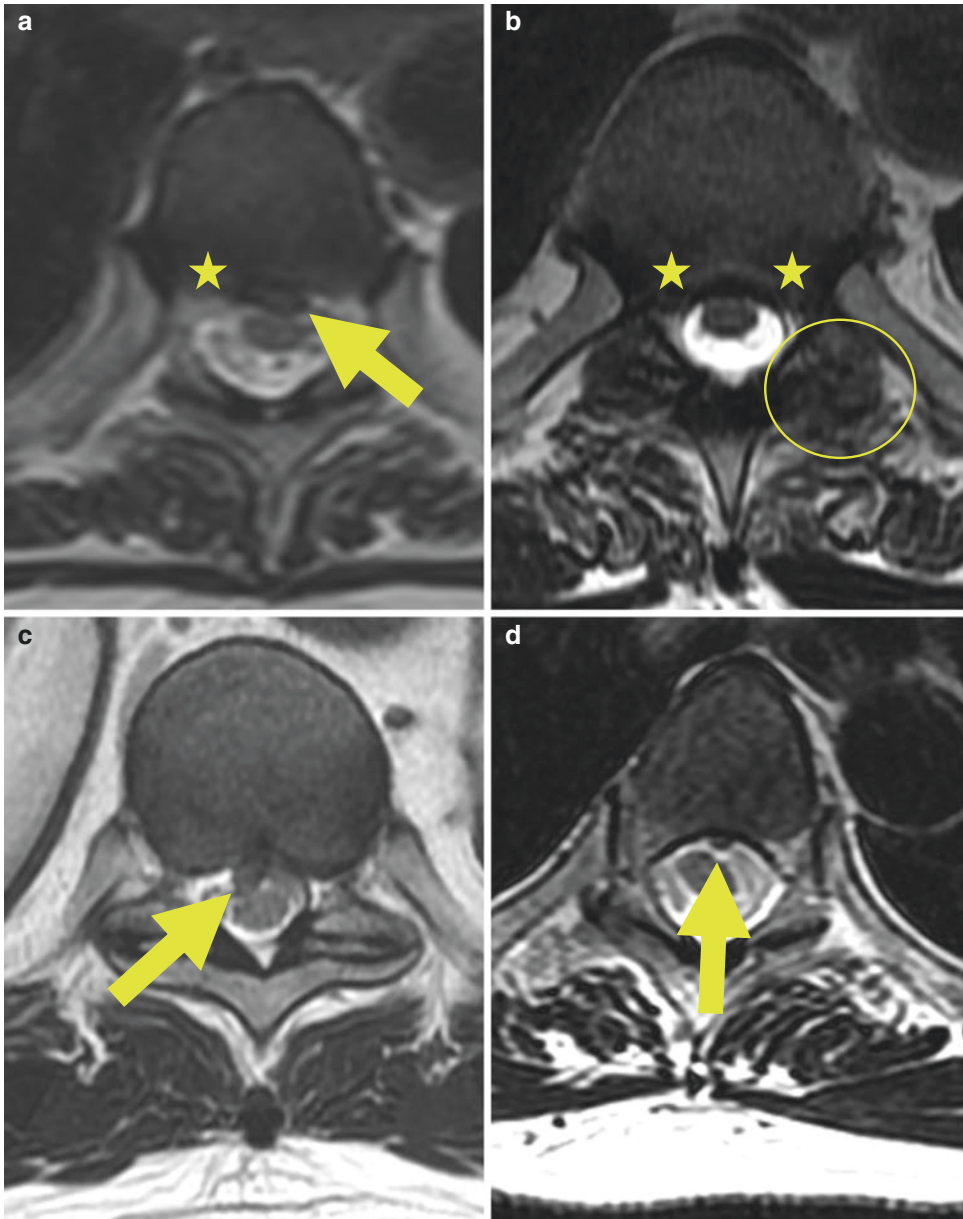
Axial T2-weighted imaging of the thoracic spine. In (a), there is a disk herniation (star) with a superimposed left central disk extrusion (arrow) which causes mild central canal narrowing. In (b), there is a diffuse disk bulge (stars) and bilateral facet hypertrophy (oval) causing
